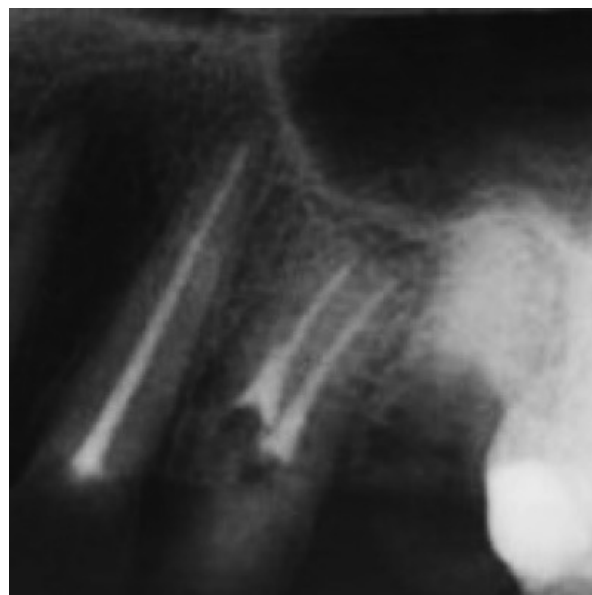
Post-operative radiograph of the tooth 24 taken after root canal obturation
